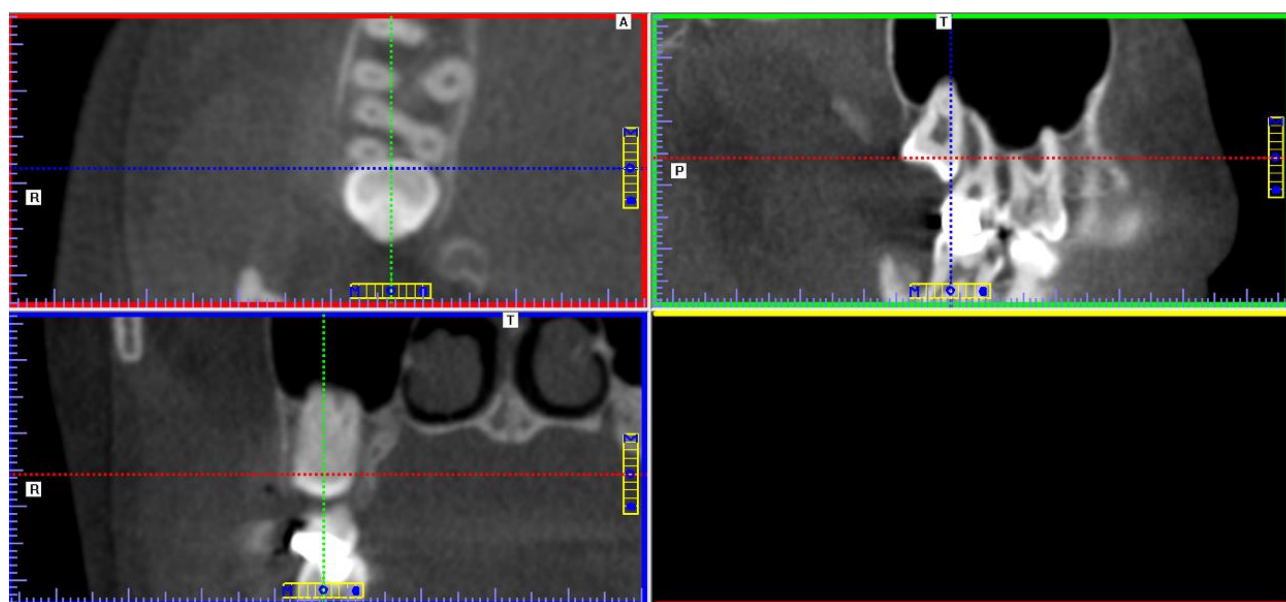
Examination of external root resorption on CBCT image (coronal, sagittal and axial sections)
